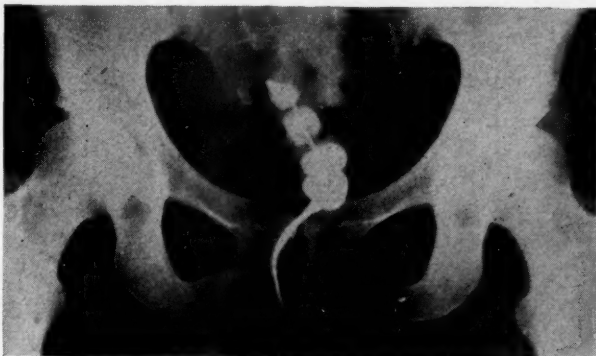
Roentgen visualization of four balloons inserted so as to record pressures simultaneously from the dome of the fundus, the main portion of the fundus, the lower uterine segment and the cervical canal. In this patient the balloons have been overdistended with 30 per cent solution of sodium iodide in order to obtain better visualization.
